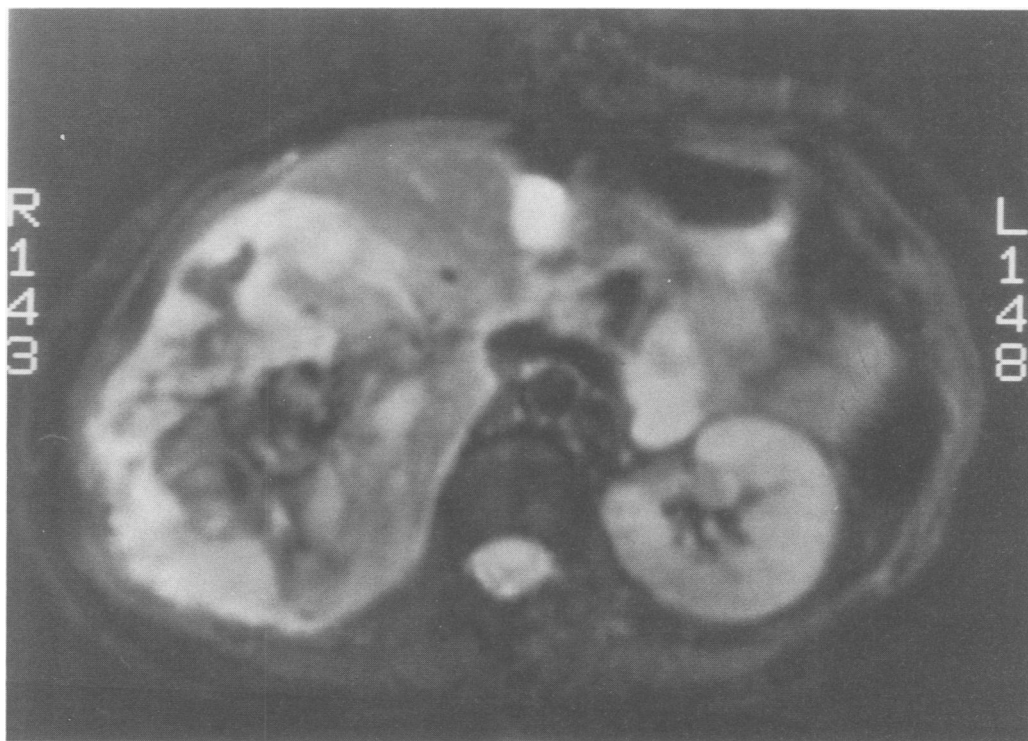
T1-weighted magnetic resonance imaging scan defining relationship of retroperitoneal sarcoma shown in Figure 1 to adjacent solid organs.
